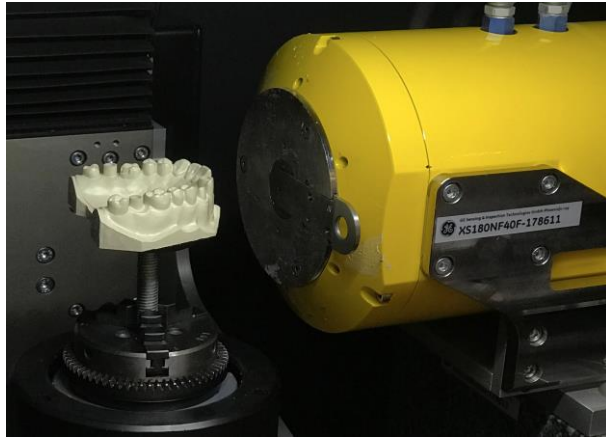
PEEK model on the rotation stage of the CT-system nanotom[®] m (Picture: M. Sacher).
